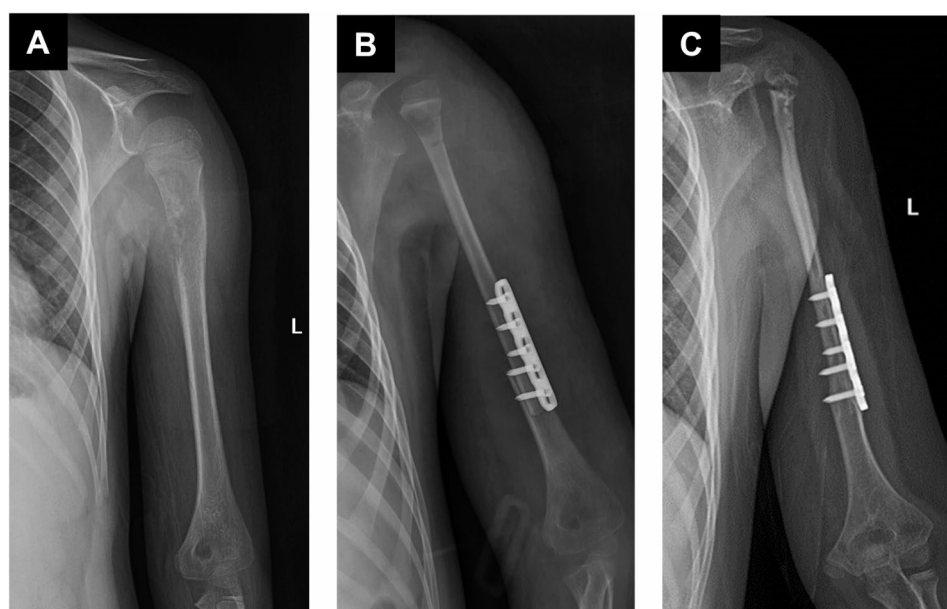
A typical case without any complications. A: Preoperative X-ray (A) of a 9-year-old male patient diagnosed with osteosarcoma in the left proximal humerus. B: X-ray at one week after surgery. C: X-ray at the last follow-up. (Case 11 in Table 1)
